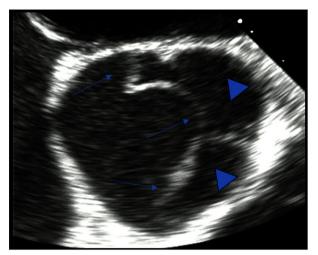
Transthoracic echocardiogram of the aortic valve, short axis view. Short axis view of the aortic valve demonstrating a dissection flap (arrows) in close proximity to, and prolapsing across, the aortic valve (triangles), with significant aortic valve regurgitation.
